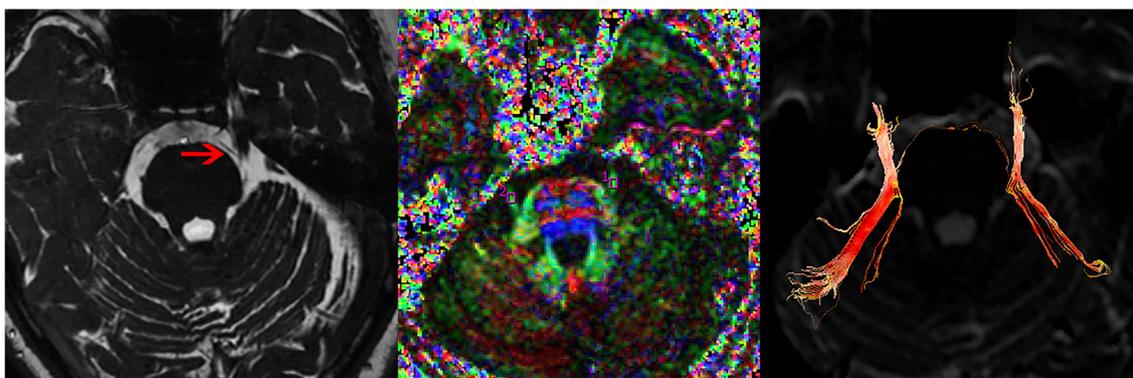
A 59-year-old female TN patient, suffering left maxillofacial pain for more than 1 year. a 3D-FIESTA MRI shows span of SCA (arrow) near the root entry zone (REZ) of the trigeminal nerve. b ROIs were manually
